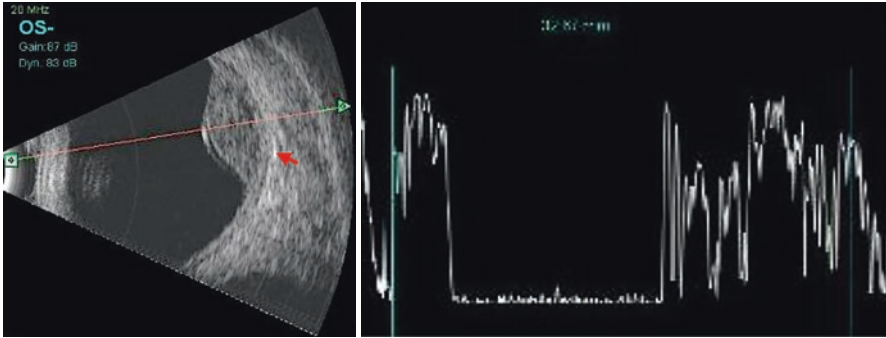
Ultrasonography of choroidal metastases The lesion is dome shaped with a higher base to height ratio. The underlying choroid is intact without excavation (red arrow). A scan shows medium internal reflectivity. Overlying retinal detachment is evident.
